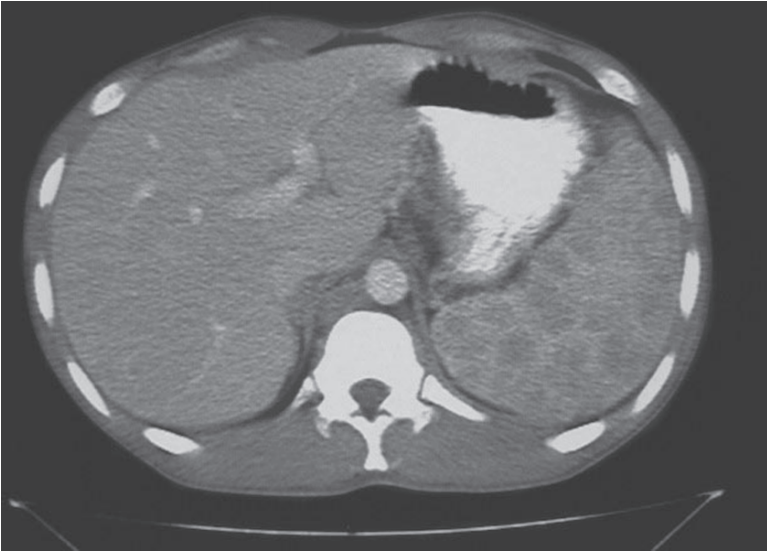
CT image of a 42-year-old male patient with non-Hodgkin's lymphoma. There are multiple low attenuation lesions within the spleen
